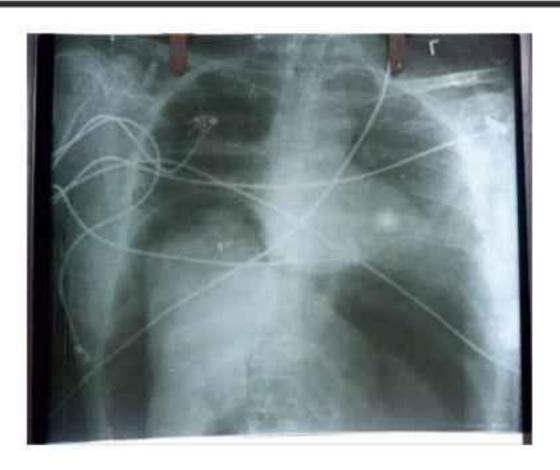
1 Chest X-rays of the patient :
